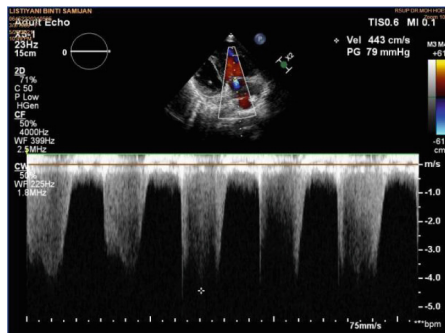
Echocardiography ASD showed tricuspid regurgitation with pressure gradient 79 mmHg after ASD closure
